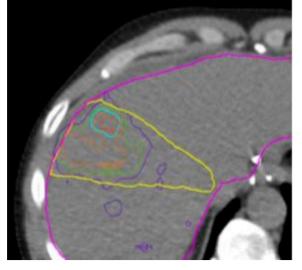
Post-treatment CT from Fig. 3 with Y90 radioactivity data replaced with isodose lines created using MIM software. Isodose lines indicate 200% (red), 100% (orange), 50% (green), and 25% (blue) of prescription dose (136 Gy).
